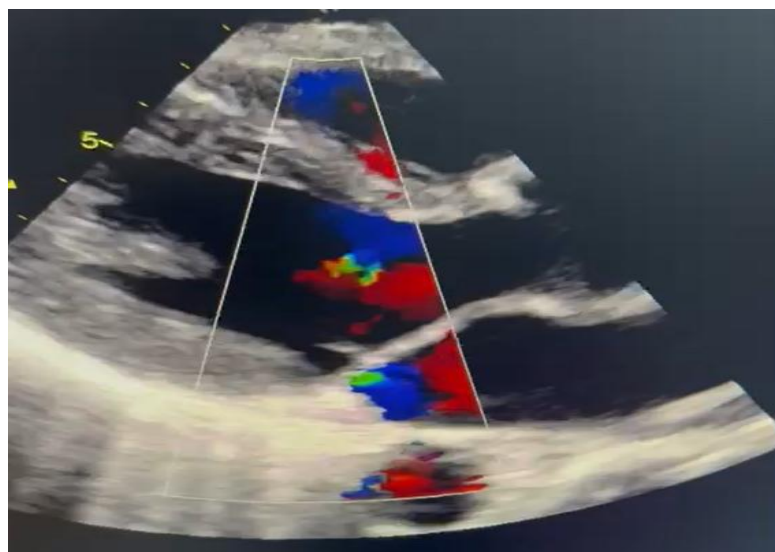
Transthoracic echocardiography, parasternal long axis, blood flow interrogation using color Doppler. An eccentric jet of mild functional mitral regurgitation is observed, caused by a slight mitral valve prolapse. (From personal archive)
